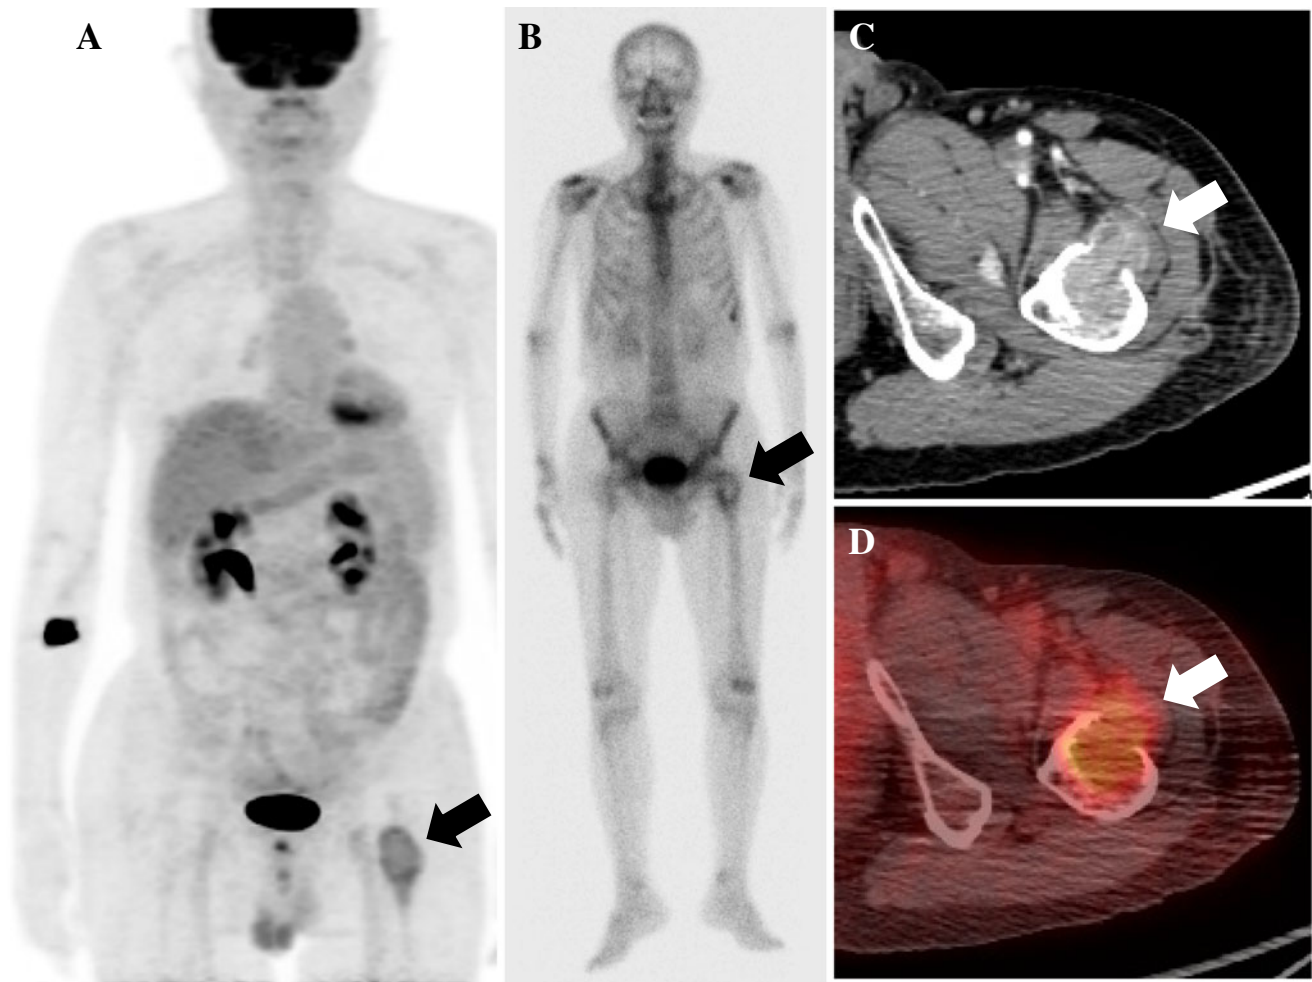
A 72-year-old man diagnosed with hepatocellular carcinoma with a history of transarterial catheter embolization. During follow-up, the patient complained of bone pain in the left proximal femur with elevated AFP (6,911.73 IU/ml). a PET/CT showed increased FDG uptake at the left proximal femur. b Whole-body bone scintigraphy
